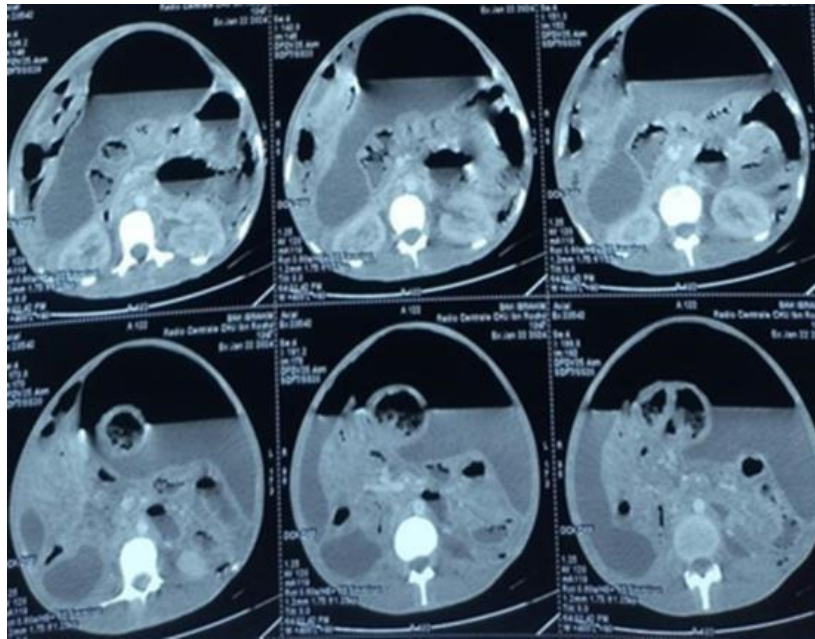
Computed tomography scan image
